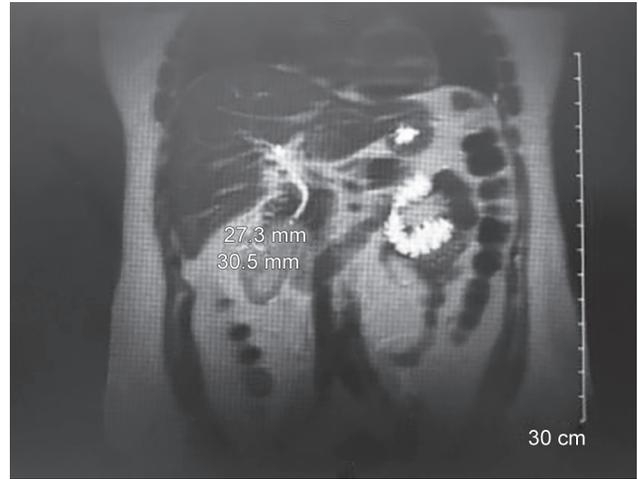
MRI of the abdomen showing complex renal mass measuring 28 × 31 mm
